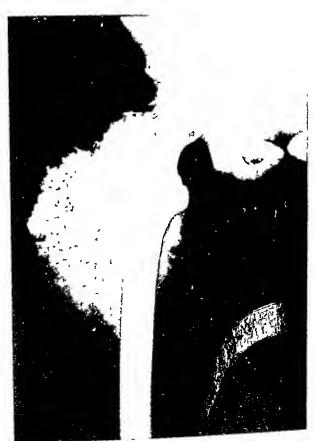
Roentgenogram of a peripheral type of chondrosarcoma arising from the cartilaginous cap of a pre-existing cartilaginous exostosis in a 21-year-old girl
